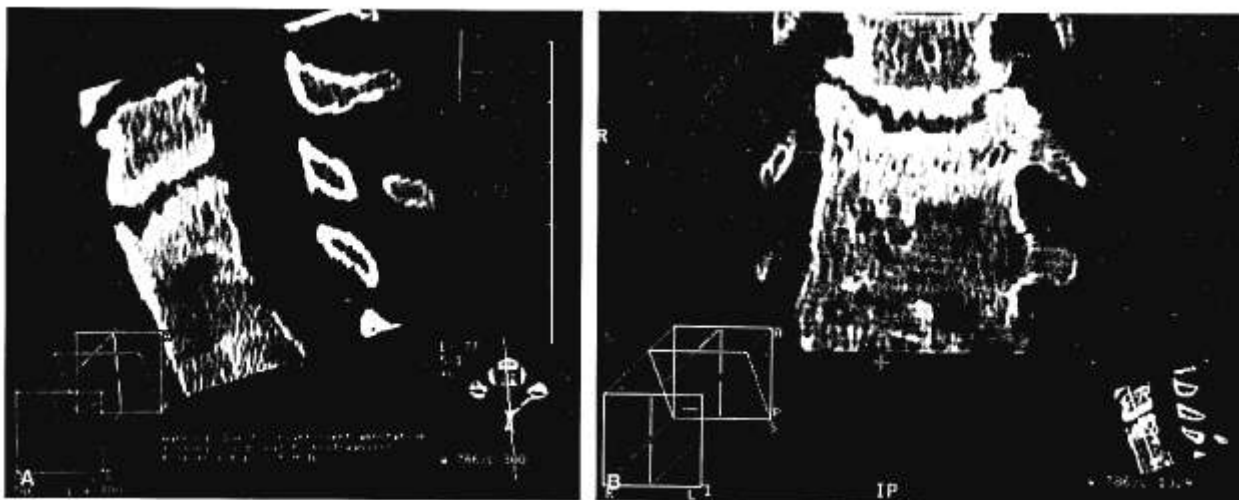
Sagittal (A) and coronal (B) computed tomography scan reconstruction of C4-5, demonstrating the pseudarthrosis after arthrodesis with autologous iliac crest bone graft alone.
